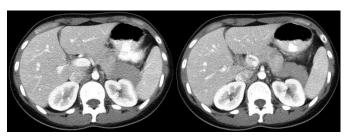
Computed tomography showing edematous pancreatitis, predominantly at the tail of the pancreas.
